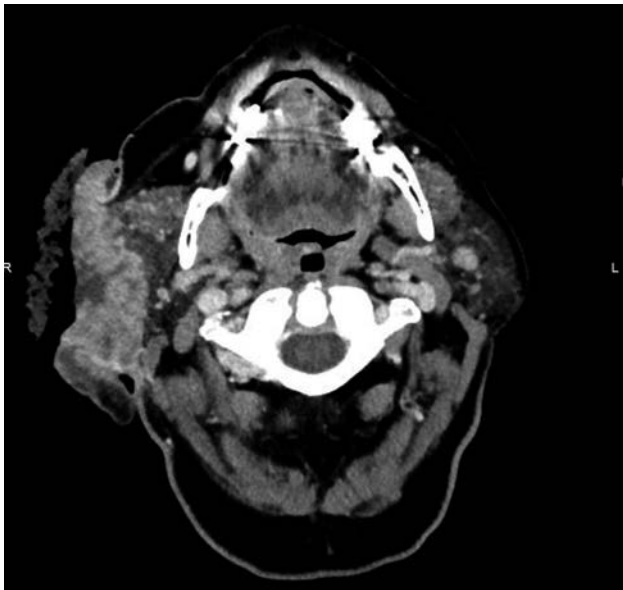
Computed tomography scan of the skull showing an expansive, centrally necrotic tumour on the right cheek reaching from the temporal to the cervical region with evidence for infiltration of the parotid gland, right masseter muscle and right auditory canal.
